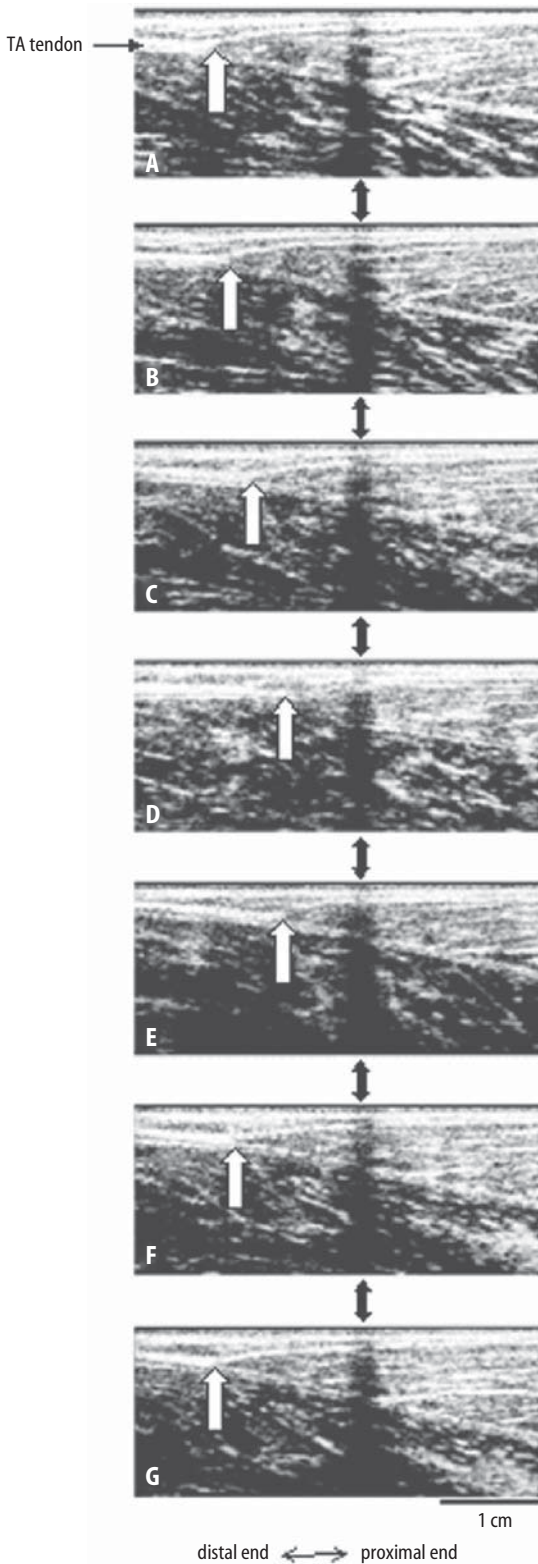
Typical in vivo sonographs of the human tibialis anterior (TA) tendon. (A) resting state; (B) 40% of maximal isometric contraction during activation; (C) 80% of maximal isometric contraction during activation; (D) 100% of maximal isometric contraction; (E) 80% of maximal isometric contraction during relaxation; (F) 40% of maximal isometric contraction during relaxation; (G) 0% of maximal isometric contraction at the end of relaxation. The white arrow in each scan points to the TA tendon origin. The black double arrows point to the shadow generated by an echo-absorptive marker glued on the skin to identify any displacements of the scanning probe during muscle contraction–relaxation. The tendon origin displacement is larger during relaxation compared with contraction at each loading level, indicating the presence of mechanical hysteresis in the tendon.²¹
